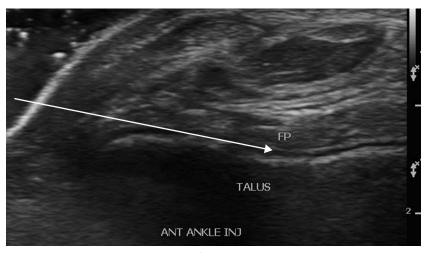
Sonographically guided injection of ankle joint, short axis to joint, needle in plane with transducer. Arrow delineates path of needle. Note gel standoff window to left of skin to improve placement of the needle. Left, lateral; right, medial.
